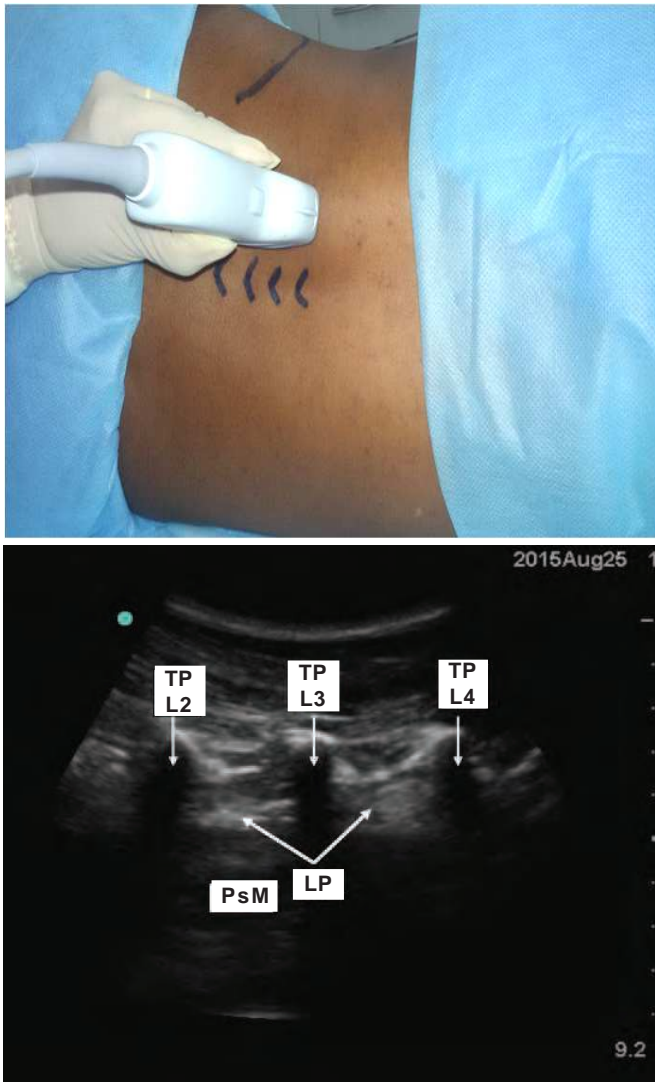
Lumbar plexus block. The ultrasound transducer is placed 3 to 4 cm lateral and parallel to the lumbar spine to scan the lumbar paravertebral region
